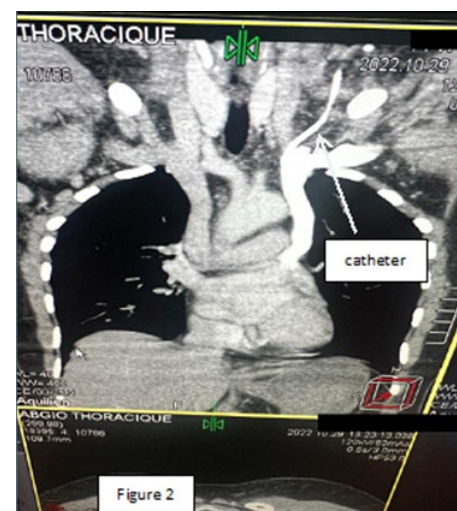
CT scan showing the left vena cava with medium contrast.
